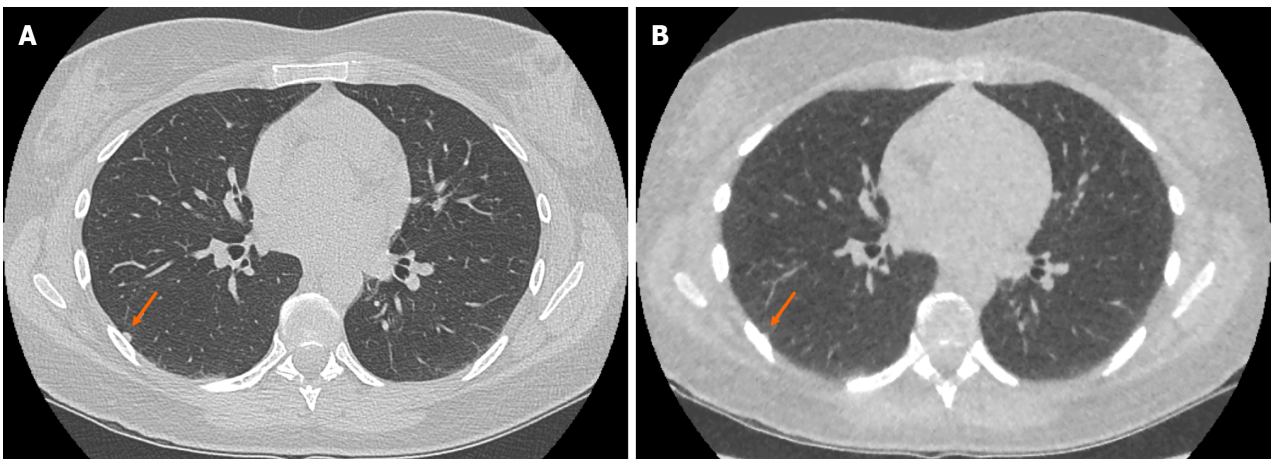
Example of false negative pulmonary nodule identification on ultra-low-dose computed tomography chest. A: Selected axial slice of a standard dose computed tomography (CT) chest presented in lung windows with a solid pulmonary nodule abutting the pleura in the lateral segment of the right lower lobe (arrow); B: Selected axial slice of an ultra-low dose CT chest with model-based iterative reconstruction in the same patient at the same level presented in lung windows demonstrating the less conspicuous pulmonary nodule that was not identified (arrow). The incidence of false negative solid nodule identification was minimal and did not reach statistical significance.
